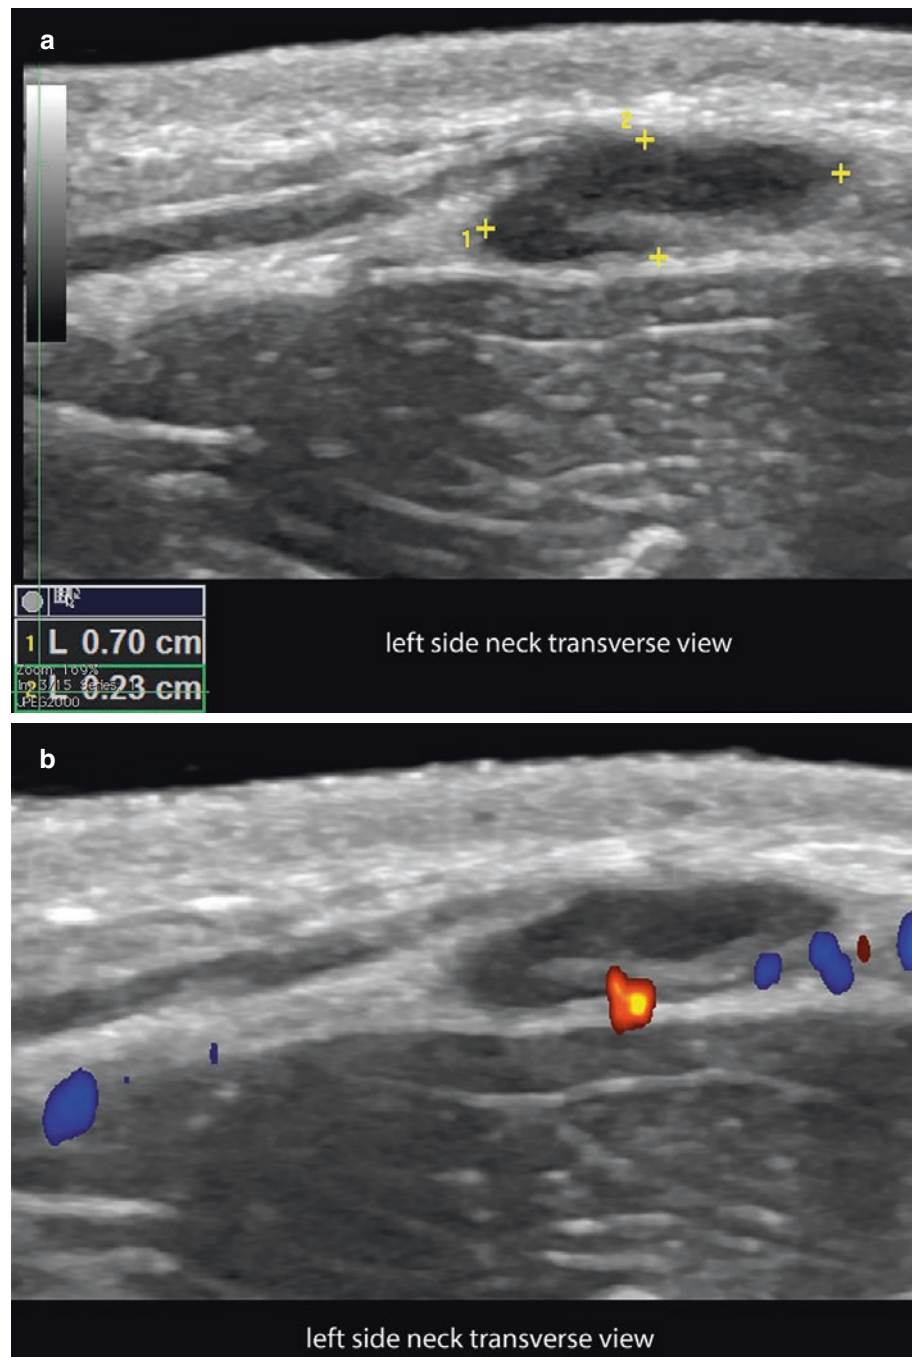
Normal ultrasound anatomy of the lymph node (transverse views; left side of the neck). (a) Greyscale (between markers). (b) Color Doppler (transverse view). Notice the normal size (0.7 cm transverse axis), the oval shape, the hypoechoic band of the cortex, and the hyperechoic center of the medulla. On color Doppler, the vascular hilum is located at the deep border.
